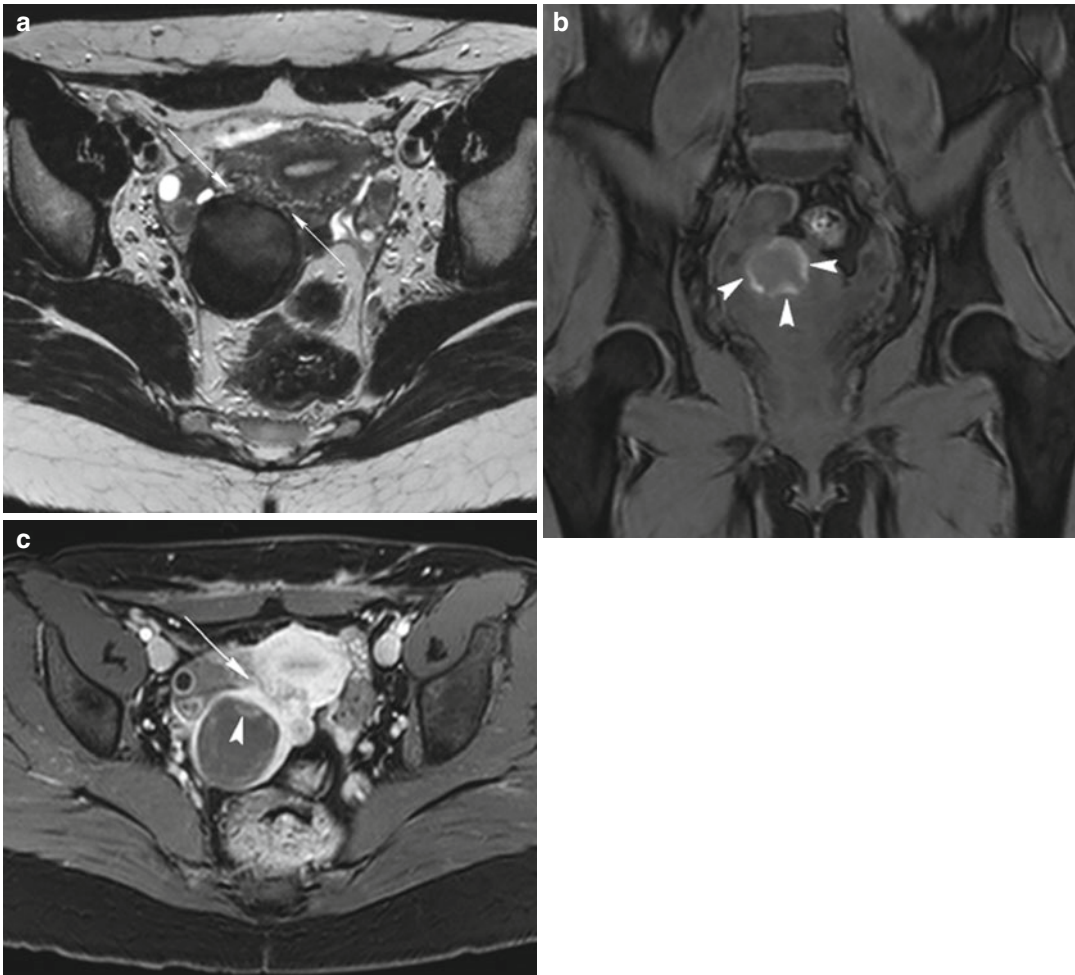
Pedunculated subserosal fibroid with intratumoral hemorrhage. Axial T2-weighted image (TR 4,800 ms, TE 120 ms) (a) shows a large well-defined pedunculated subserosal fibroid with heterogeneous low signal intensity; it has a narrow stalk (*arrow* in a and c). Coronal fat-suppressed T1-weighted (TR 4 ms, TE 2 ms) (b) and axial contrast-enhanced fat-suppressed T1-weighted
